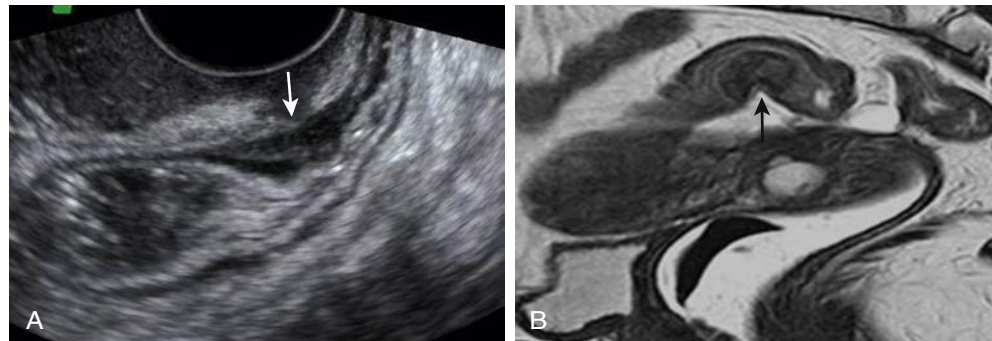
Rectal endometriosis infiltrating part of the muscular wall of the intestine by vaginal ultrasound (A) and sigmoid endometriosis infiltrating part of the muscular wall of the intestine by MRI (B). Arrows show the lesions. (Courtesy of Manoel Goncalves, MD, Clinica Medicina da Mulher and RDO Medicine Diagnostica, and Mauricio Abrao, MD, University of Sao Paulo, Sao Paulo, Brazil.)
